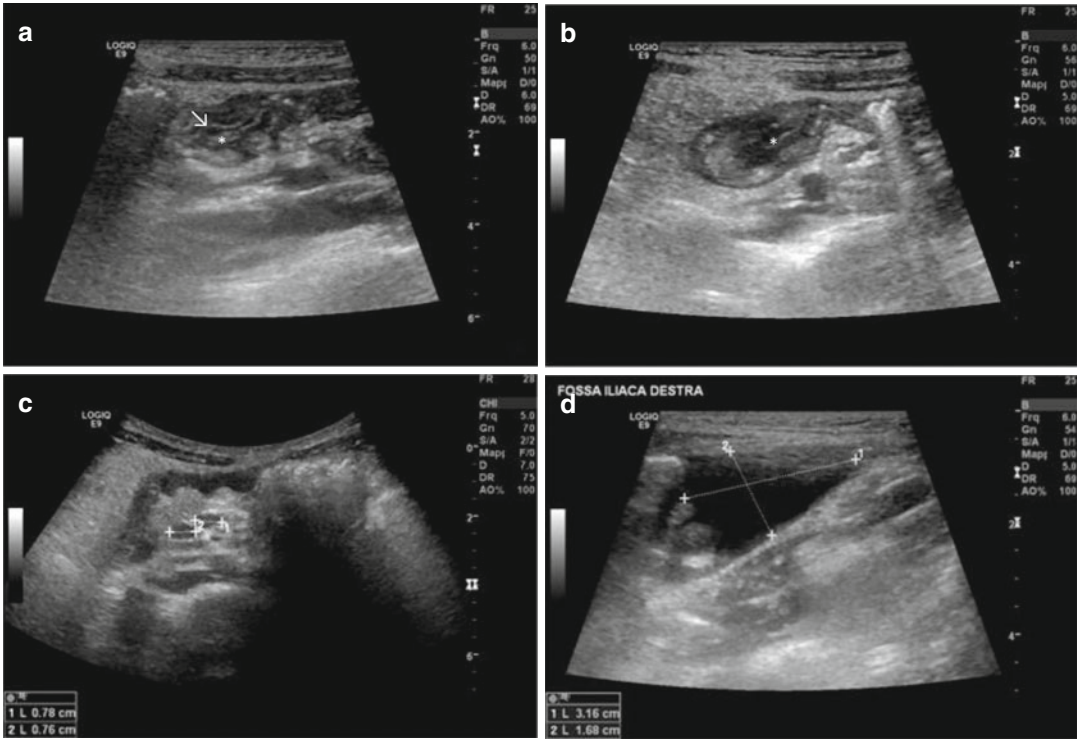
Ultrasonographic features of inverted Meckel’s diverticulum with ileocolic intussusception. (a) The transverse view shows the *double target sign*: alternating concentric layers of high and low echogenicity with an additional central area of hyperechogenicity, composed of mesenteric fat (*) and small mesenteric lymph nodes (arrow). (b) The longitudinal view of the same area shows invaginated mesenteric fat (*) within the colon (intussusciptens). (c) The adjacent mesentery appears thickened and edematous, with reactive lymph nodes. (d) A moderate amount of pelvic free fluid is found
